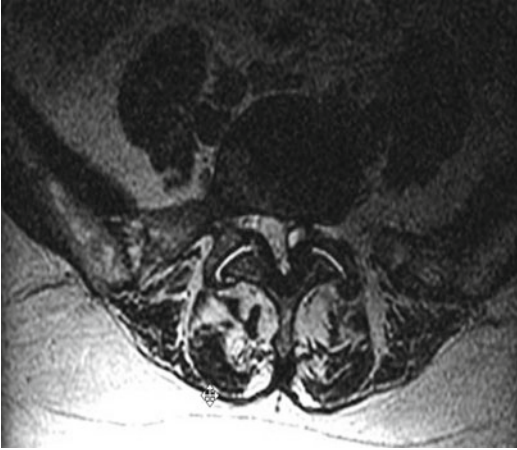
Axial T2 MRI demonstrating a left-sided facet cyst
